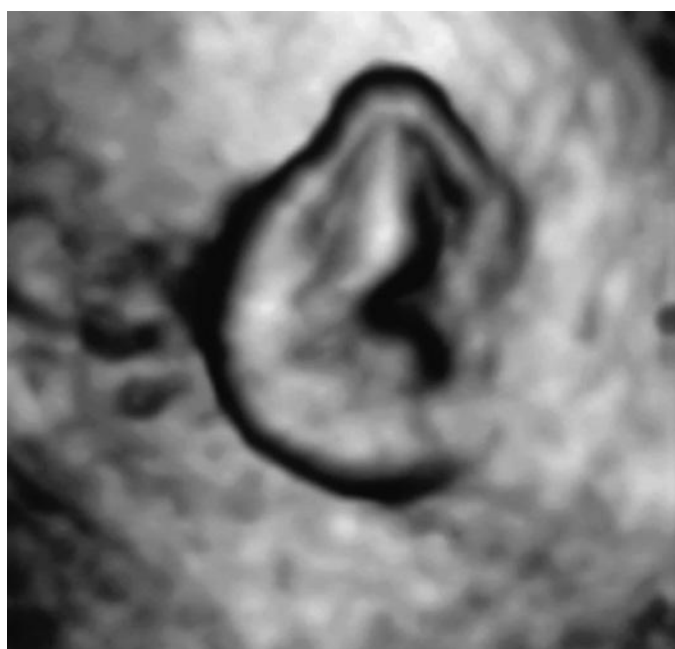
Three-dimensional ultrasound image of abnormal ear. Unfurled ear at 33 weeks; fetus had tetralogy of Fallot and mother had coarctation of aorta. Both mother and neonate had unilateral abnormal ears.
